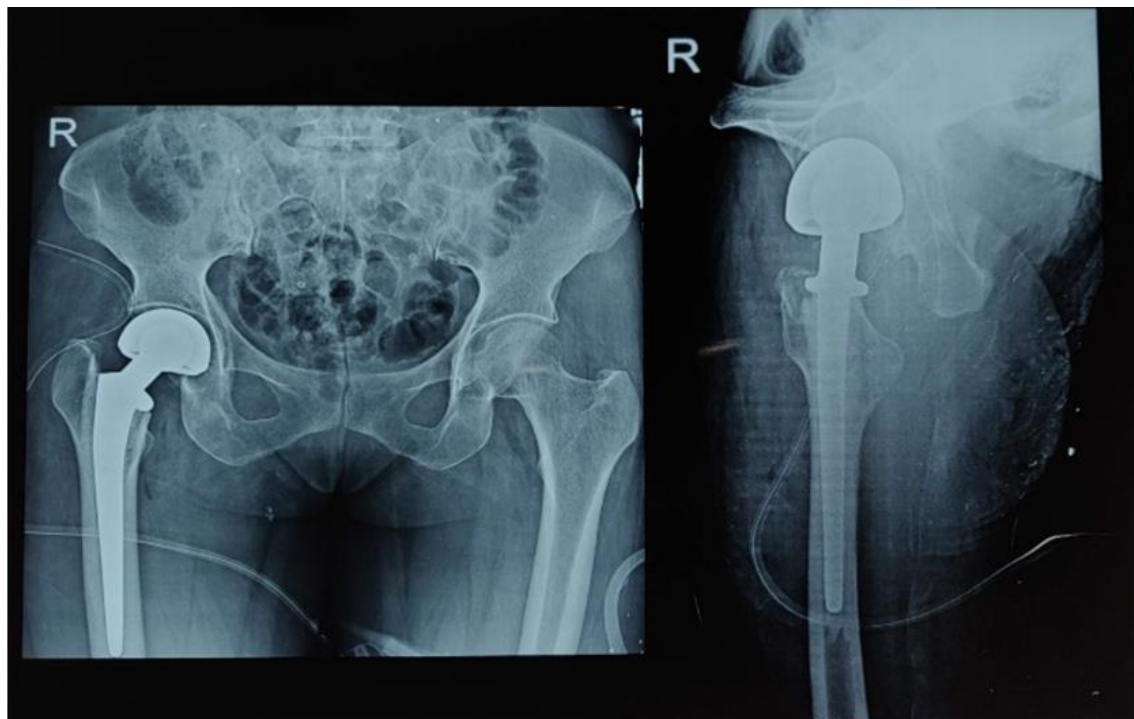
Postoperative x-ray
